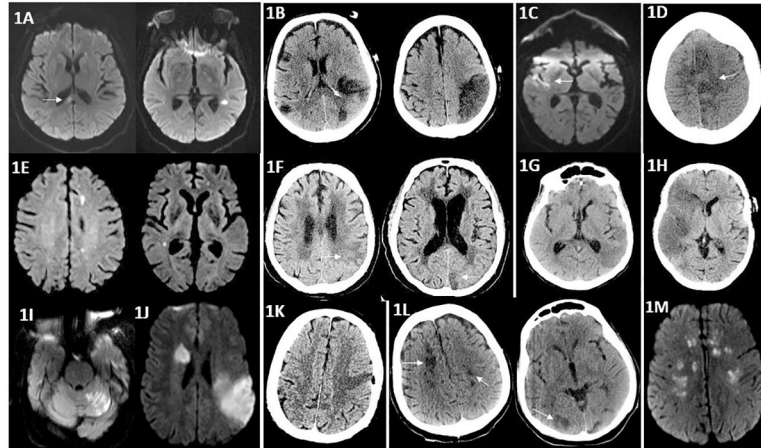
(A–M) Imaging characteristics of ischemic stroke in COVID-19 patients. A: MRI of the brain showing areas of infarction in the right corpus callosum and left temporal lobe on the diffusion-weighted sequence. B: CT brain showing hypodensities in the bilateral middle cerebral artery territories. C: MRI brain showing a right-sided temporal lobe infarction on the diffusion-weighted sequence. D: CT head showing hypodensity in the left anterior cerebral artery territory. E: MRI brain showing areas of infarction in the left frontal and right temporal lobes on the diffusion-weighted sequence. F: CT head showing hypodensities correlating with infarctions in the left parietal and occipital lobes. G: CT head showing a hypodensity in the left temporal lobe. H: CT head showing a large infarction in the right middle cerebral artery territory. I: MRI brain showing area of infarction in the left superior cerebellum on the diffusion-weighted sequence. J: MRI brain showing areas of infarction in the right corona radiata and left parietal lobe on the diffusion-weighted sequence. K: CT head showing a hypodensity in the left frontal lobe in the middle cerebral artery territory. L: CT head showing bilateral infarctions involving the anterior and posterior circulations. M: MRI head showing bilateral frontoparietal centrum semiovale/corona radiata infarctions on the diffusion-weighted sequence.
